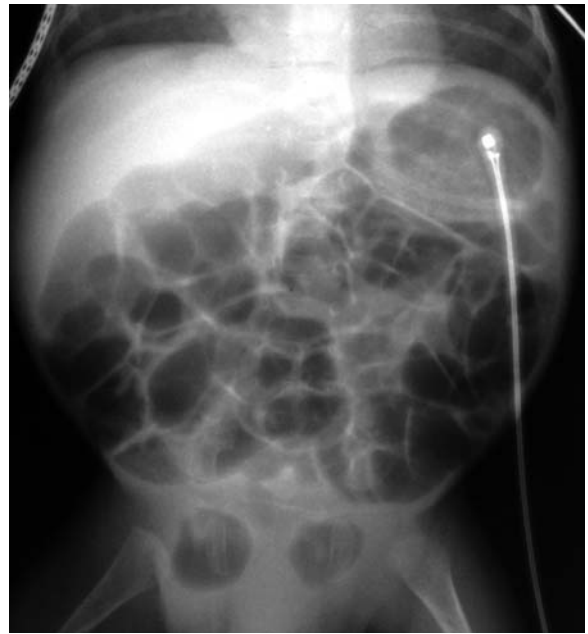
Hernia on plain film
